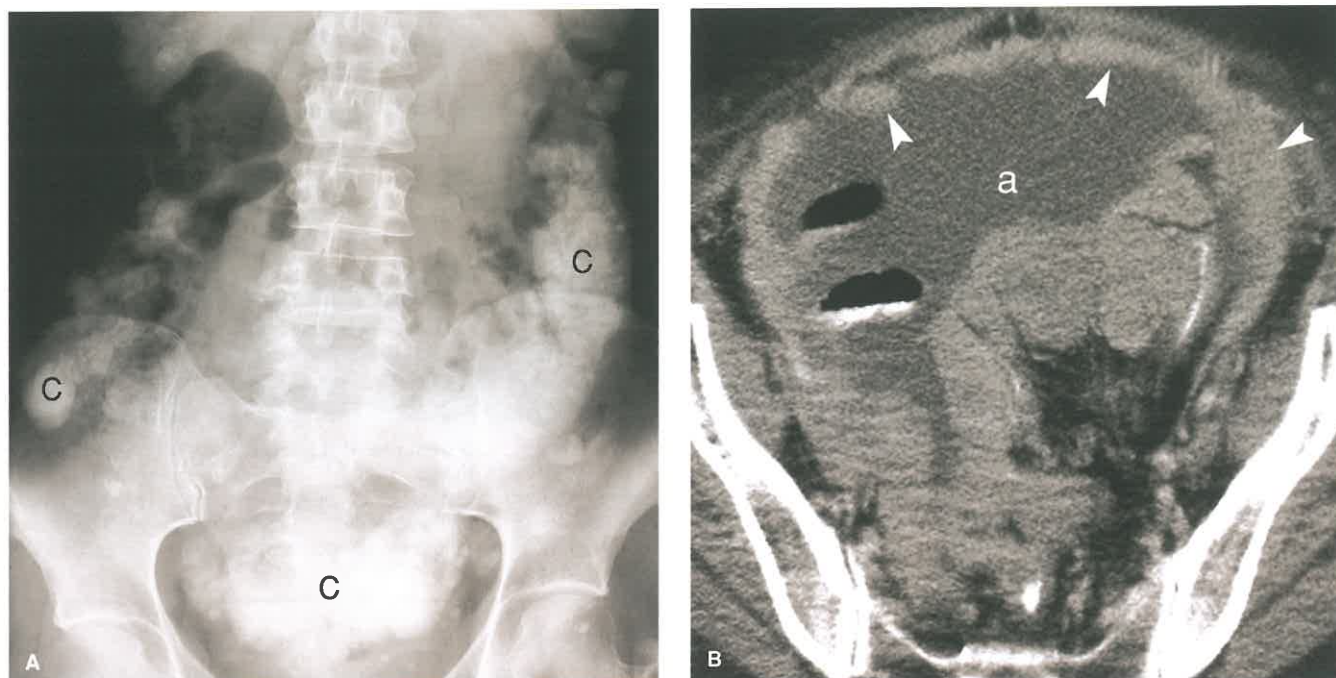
Peritoneal Metastases From Ovarian Carcinoma. A: Conventional radiograph of the abdomen demonstrates calcified implants of ovarian carcinoma (C) throughout the peritoneal cavity. The pathologic diagnosis was metastatic papillary serous cystadenocarcinoma of the ovary. B: CT image reveals nodular tumor implants (arrowheads) on the parietal peritoneum well outlined by ascites (a). The patient had metastatic ovarian carcinoma.
